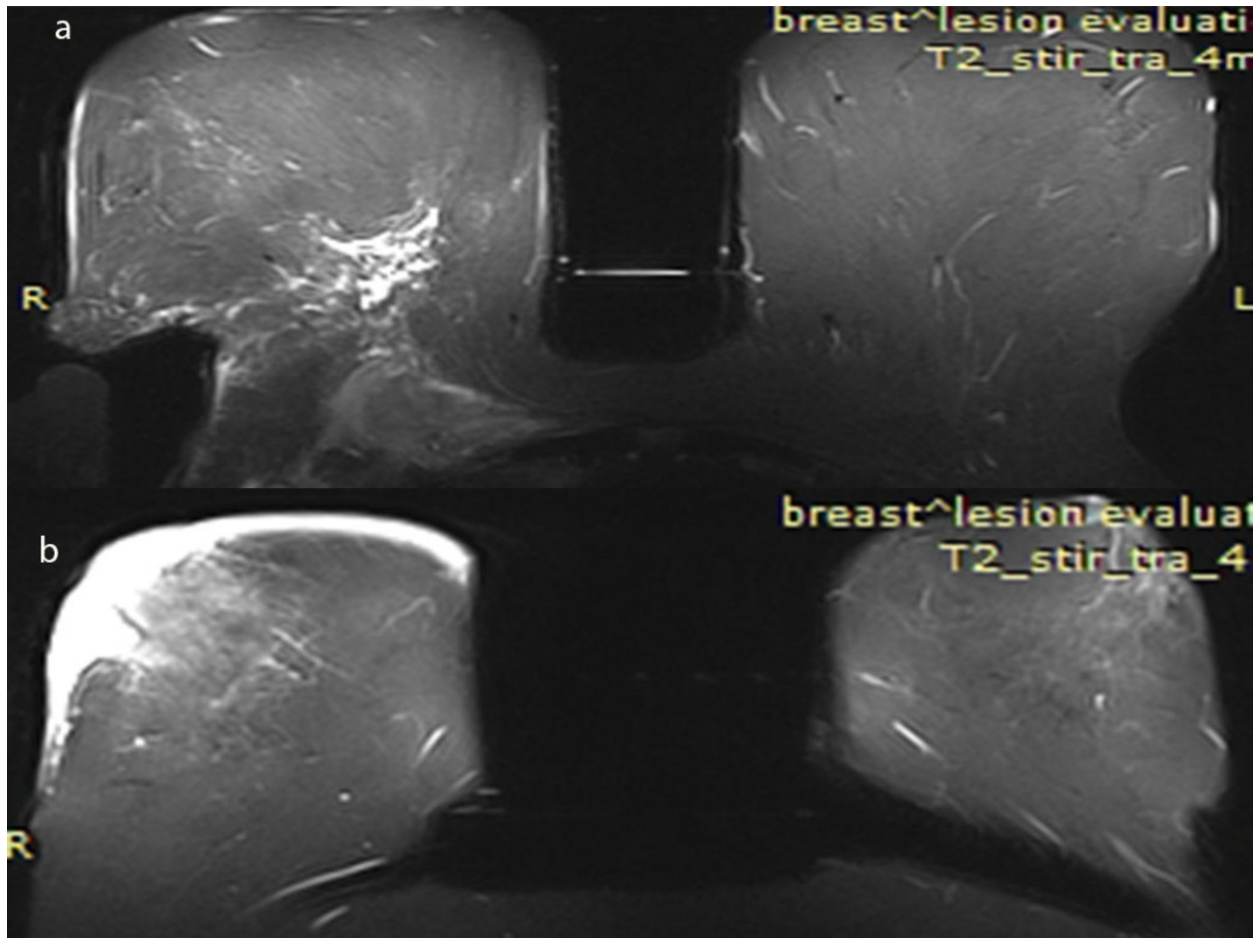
Breast MRI T2 STIR axial image. A. The right breast has diffuse trabecular hyperintensity, more intense posteriorly abutting the pectoral muscles. B. Skin oedema.
